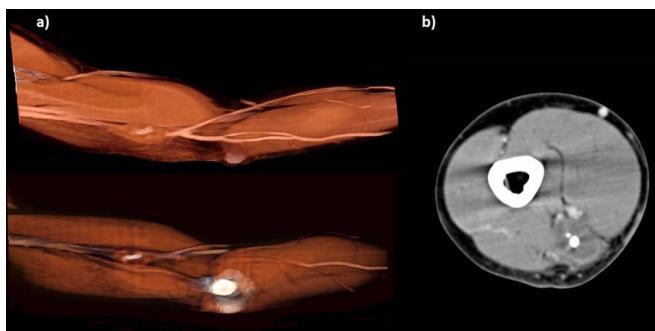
a) 3D reconstruction left arm, basilic vein dependent tumor is observed b) CT axial section where tumor is observed between the compartments arm.
